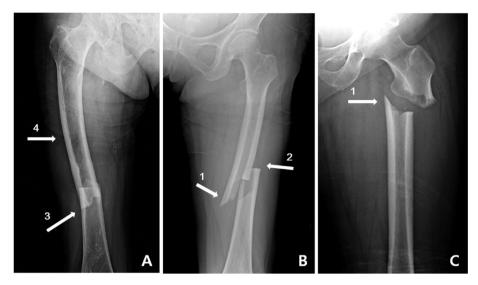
Radiographs of the atypical femoral fracture. (A, B) shows atypical femoral fracture in femoral shaft region, and (C) in the subtrochanteric area. The radiographic features of atypical femoral fractures: (1) medial spike; (2) transverse fracture pattern (3) localized periosteal thickening of the lateral cortex; (4) generalized thickening of the femoral cortices.
